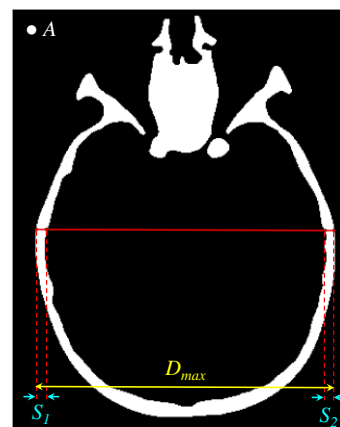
Slice of the sample CT in which the measured quantities being compared are shown. A : area of skull section (white pixels); D_{max} : maximum longitudinal diameter; S_1 and S_2 : skull thicknesses at D_{max} .
